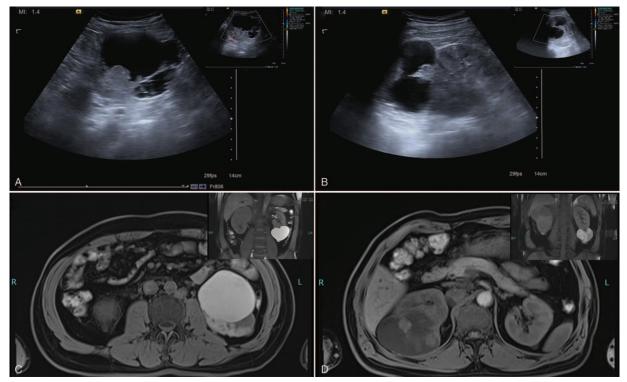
(A) Ultrasound showing a hybrid echo (cystic-solid) mass in the left kidney. (B) Ultrasound showing a hybrid echo (cystic-solid) mass in the right kidney. (C) Cross section of MRI showing a (cystic-solid) mass in the right kidney. The coronal image is in the inset.
